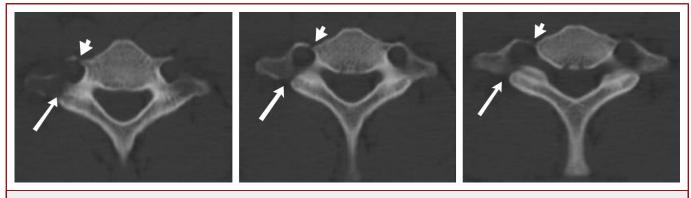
Fine computed tomography sequential axial cuts through C7 demonstrate the minimally displaced fracture through the transverse process on the right (arrow), extending into the foramen transversarium (arrowhead).
